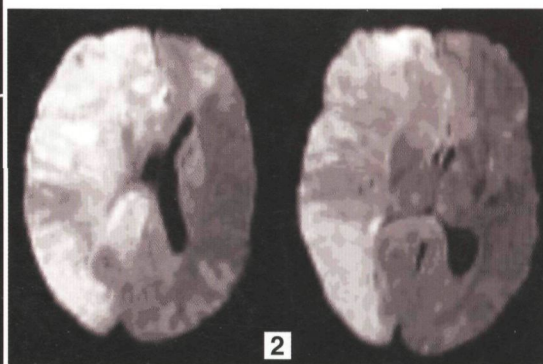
Case #1 Whole brain CT perfusion. Prolonged mean-transit time (MTT) and time-to-peak (TTP) is evident in the majority of the right hemisphere, as well as in the left frontal and parietal lobes. Slight reduction in cerebral blood flow is also evident in these locations.
